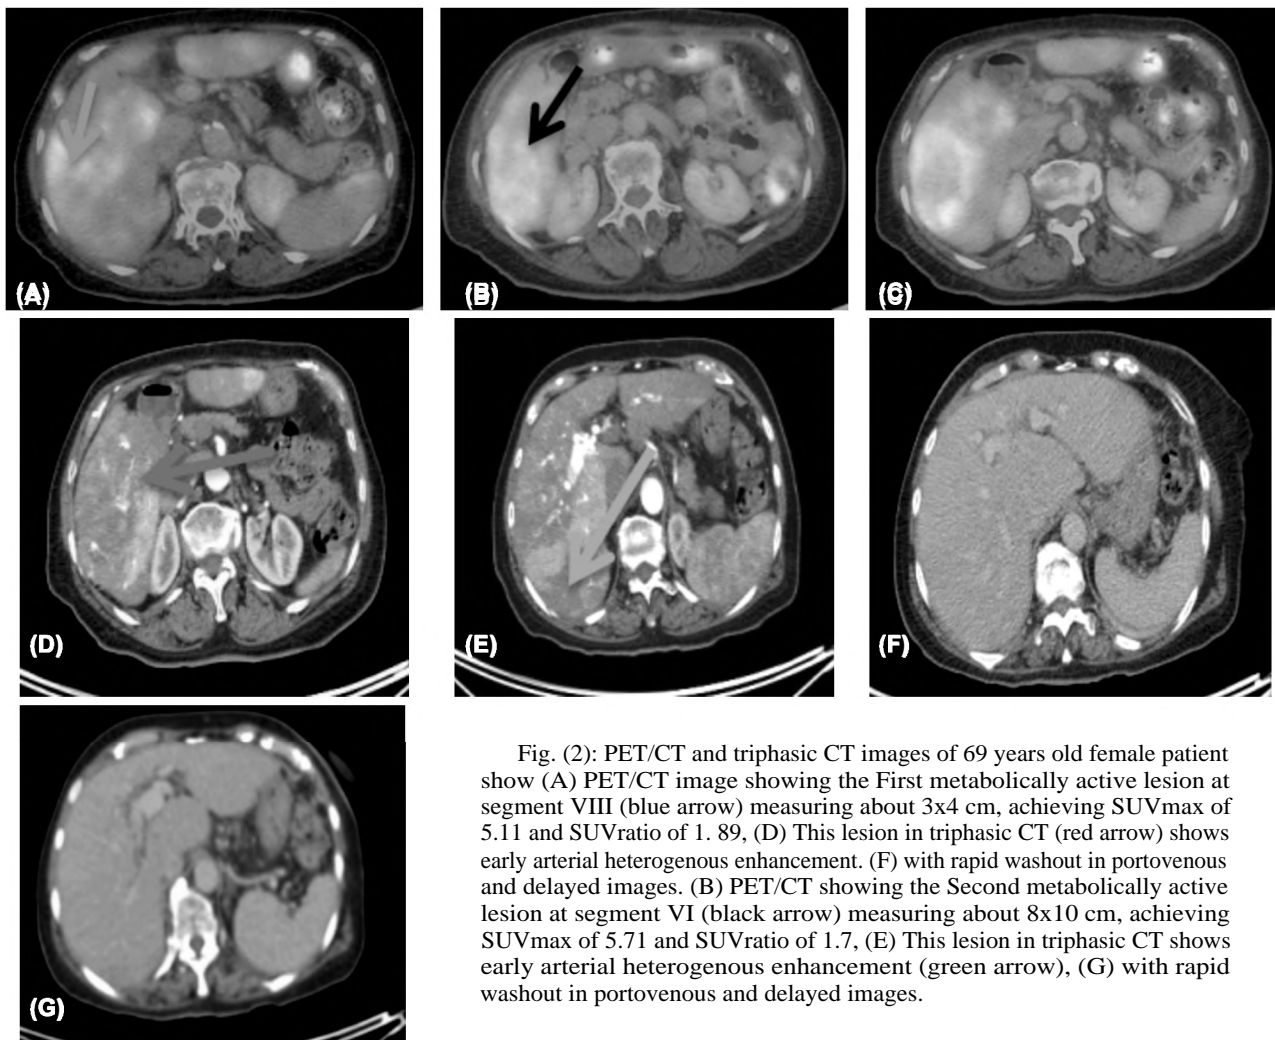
PET/CT and triphasic CT images of 69 years old female patient show (A) PET/CT image showing the First metabolically active lesion at segment VIII (blue arrow) measuring about 3x4 cm, achieving SUVmax of 5.11 and SUVratio of 1.89, (D) This lesion in triphasic CT (red arrow) shows early arterial heterogeneous enhancement. (F) with rapid washout in portovenous and delayed images. (B) PET/CT showing the Second metabolically active lesion at segment VI (black arrow) measuring about 8x10 cm, achieving SUVmax of 5.71 and SUVratio of 1.7, (E) This lesion in triphasic CT shows early arterial heterogeneous enhancement (green arrow), (G) with rapid washout in portovenous and delayed images.
